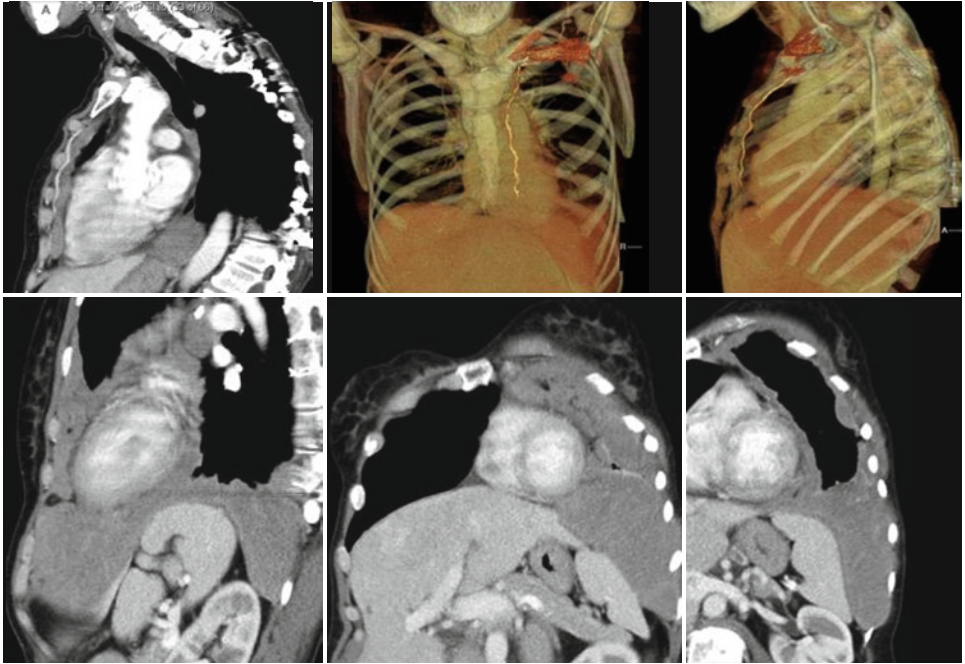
Multi-planar and Volume-rendered CT images showing relationship to mediastinal structures and vessels
